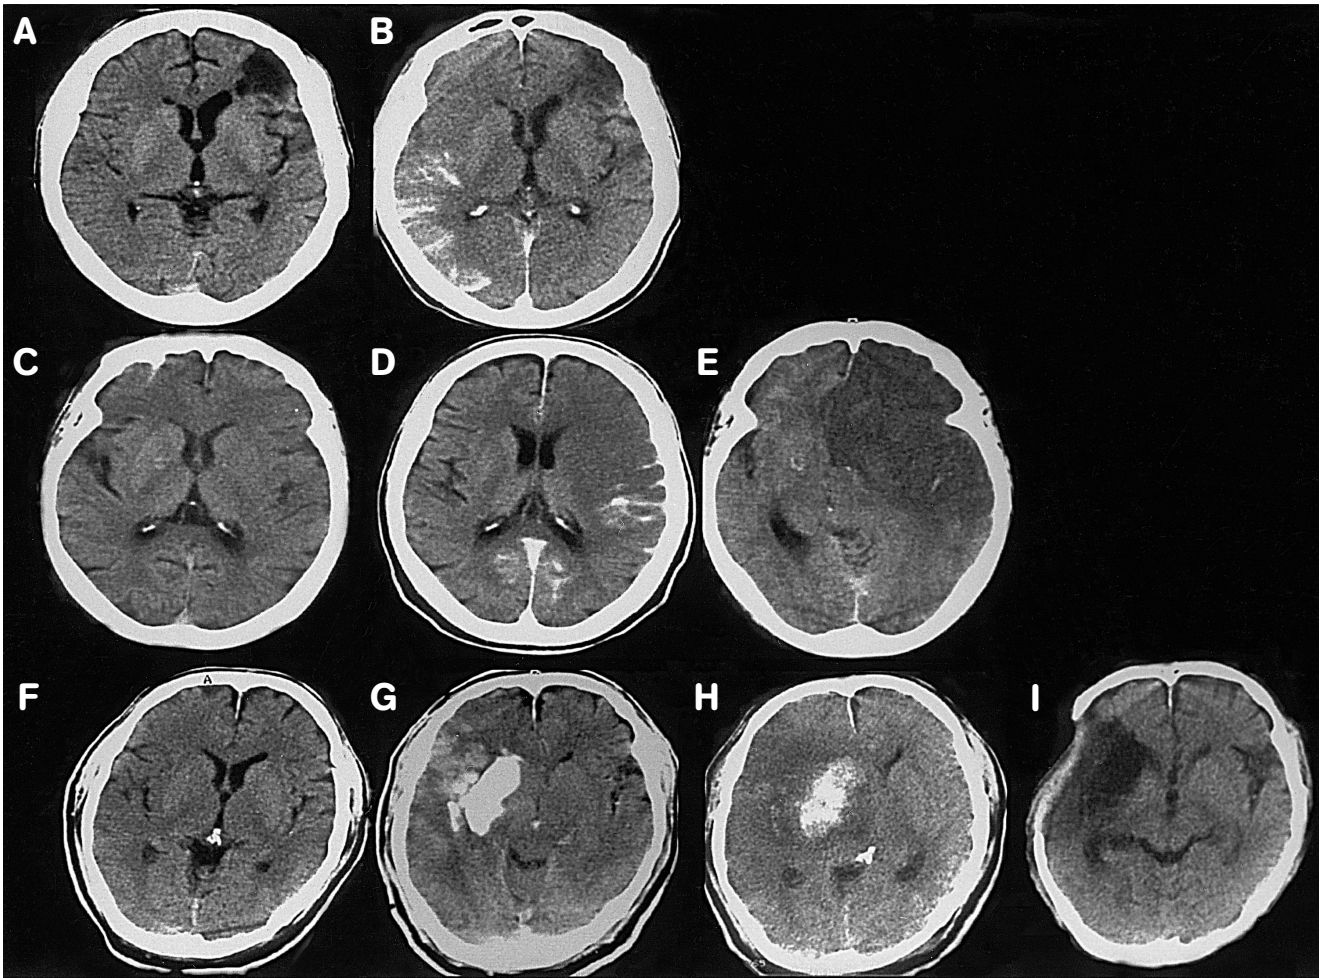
Brain computed tomography (CT) scans in three patients treated with urokinase for acute infarction. Brain CT scans of the patient 5 with acute right middle cerebral artery (MCA) occlusion and an old infarct in the left frontal area show garlandlike enhancement without hemorrhagic transformation in the cerebral cortex on the acute post-thrombolytic scan (B) compared with the pre-thrombolytic scan (A). Neuroimaging studies of the patient 6 with acute left internal carotid artery (ICA) occlusion reveal normal structures on the acute brain CT scan (C) and lesions with garlandlike enhancement with minimally decreased densities in the left MCA and anterior cerebral artery (ACA) territories on the acute post-thrombolytic scan (D). There is significant mass effect with compression of the ventricular system on the left side resulting in marked displacement of midline structures on post-thrombolytic 24 hours scans (E). Brain CT scans of the patient 7 with acute right ICA occlusion show normal structures (F). On acute post-thrombolytic scans, there is an isodense hematoma in the right basal ganglia with enhancement of the cerebral cortex and mild hypodense areas in the territories of the right ACA and MCA (G). On scans obtained 24 hours post-thrombolytic therapy, there are hematoma of the same size and conspicuous brain edema with compression of the ventricular system on the right side resulting in marked displacement of midline structures (H). There is a hypodense lesion in the right MCA territory with bony defect on scans performed 2 months after thrombolytic therapy and craniotomy (I).
